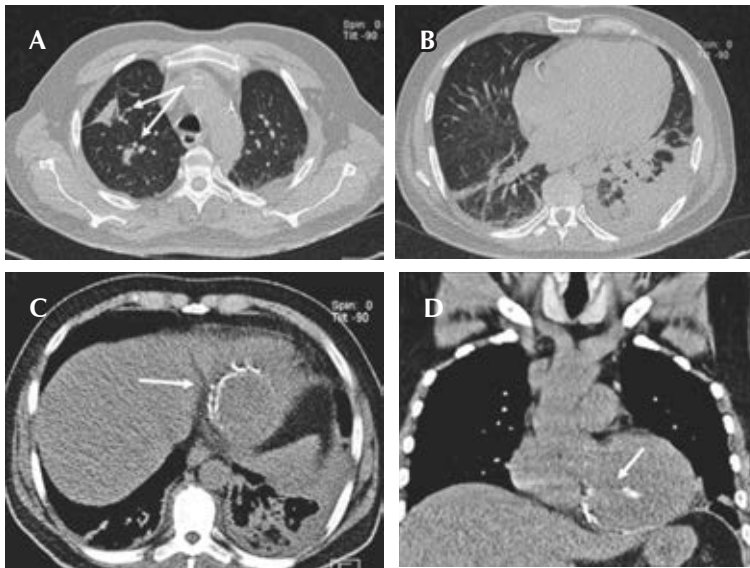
Chest CT. A, B) Multisegmental pneumonia data (arrows). C, D) Axial and coronal section. A calcified left ventricular aneurysm is observed at the basal level (arrows).
